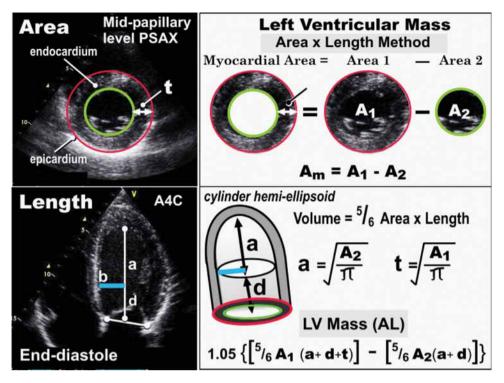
Left ventricular mass. The area-length method for using a cylinder hemi-ellipsoid of the left ventricle (LV) is the recommended equation for measuring LV mass. It is a simple formula with easily obtainable measurements. End-diastolic measurements using parasternal short-axis (PSAX) and apical four-chamber at the mid- or high-papillary muscle levels are made and inserted into the equation as shown. The sum of a + d is the end-diastolic LV cavity length; b = minor axis radius; t = mal thickness; $A_1 = mal$ total planimetered PSAX area at the mid- or high-papillary muscle level; $A_2 = mal$ LV cavity planimetered PSAX area.
